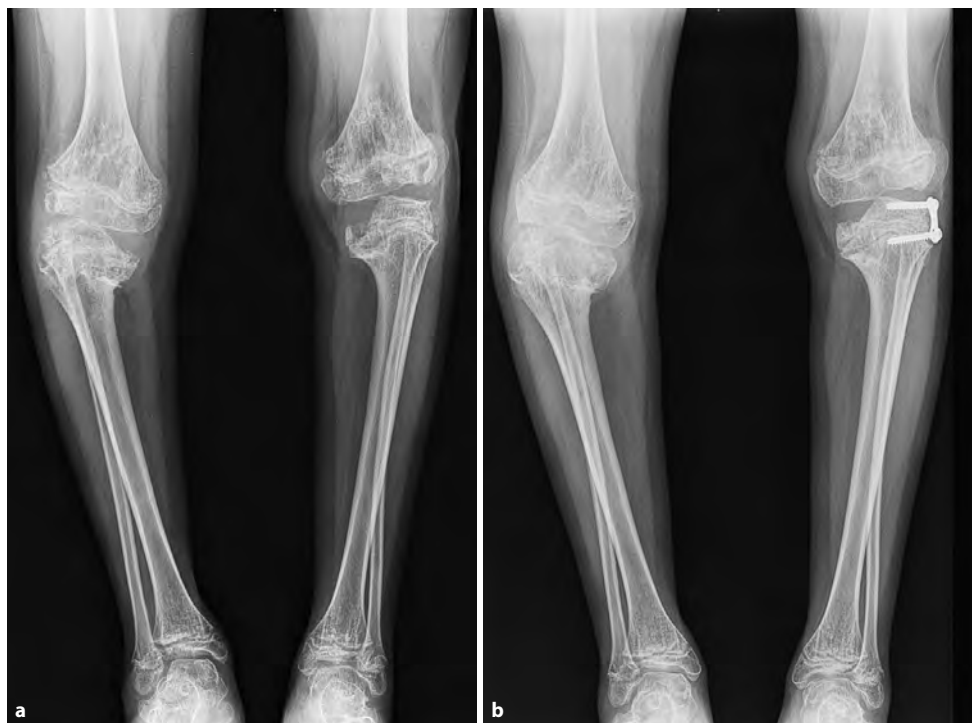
a-d: Case 1, a. X-ray of the knee joints at age 11 years showed, in addition to epimetaphyseal changes, varus of the proximal metaphysis of the tibia – more to the right, and bilateral external luxation of the patella. b. two months after temporary external hemi-epiphysiodesis of the tibia proximalis bilateralis, the eight-plate on the right side had to be removed because of infection. c. the eight-plate from the left proximal tibia was extracted at 12.5 years, i.e. 18 months after surgery, when the tibiofemoral angle of the left knee joint was satisfactorily corrected. d. X-ray of the hip joints at the age of 13 years showed very short and varus femoral necks, flattened proximal femoral epiphyses, vertical position of dysplastic acetabula and subluxation of the hip joints. The greater trochanters are in the B position (see also next page).
